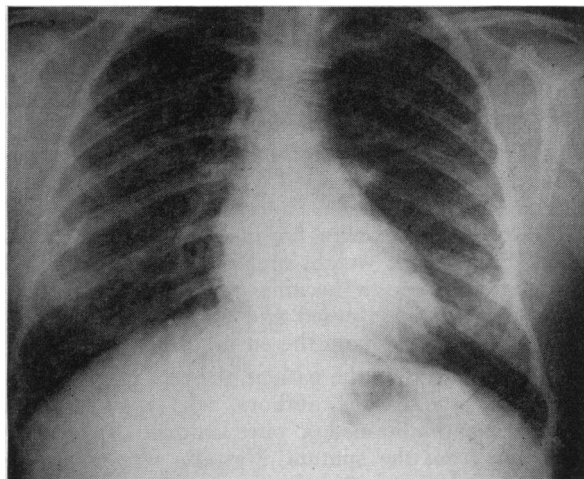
X-ray film of chest taken January 10, 1950, when patient was 17 years of age. Interpreted as showing a slight increase in the bronchovascular markings, most prominent in the right second anterior interspace.
